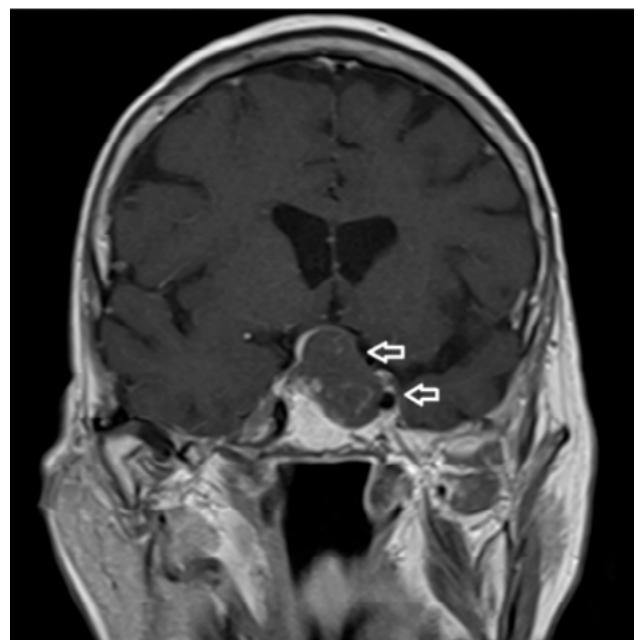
Brain magnetic resonance imaging (MRI) - T1-weighted coronal (B): "Voluminous pituitary adenoma with expression in the suprasellar cistern and left cavernous sinus and signs of hemorrhagic transformation (arrows)."
